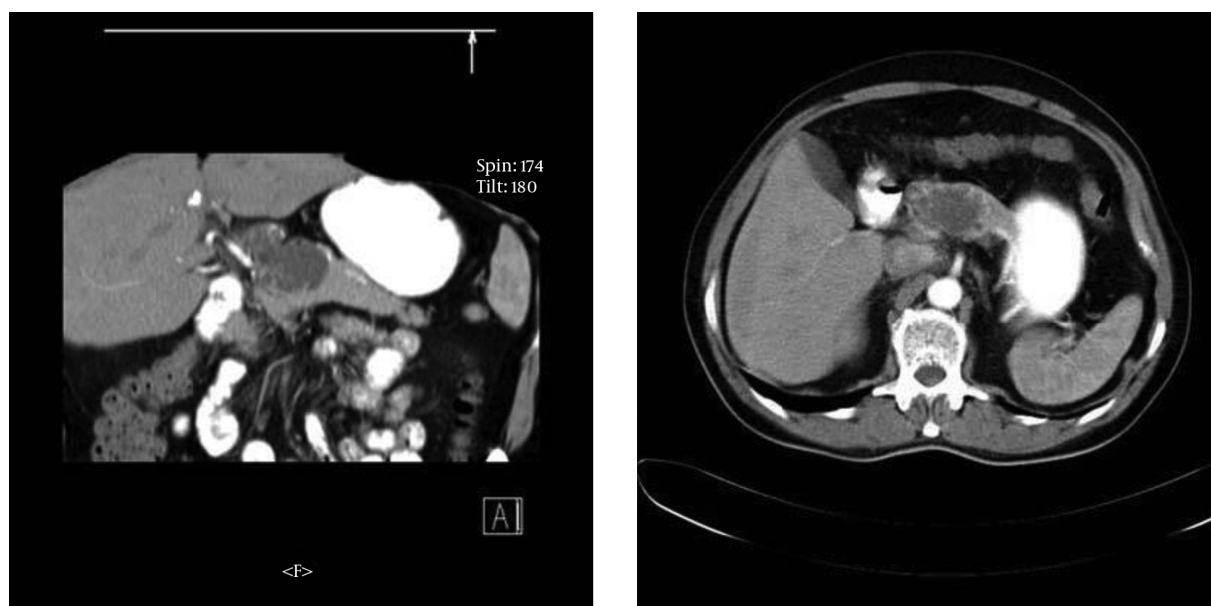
Abdominal CT Scan Showing a Lesion (Arrow) with a Well-Defined Margin in the Head of the Pancreas
